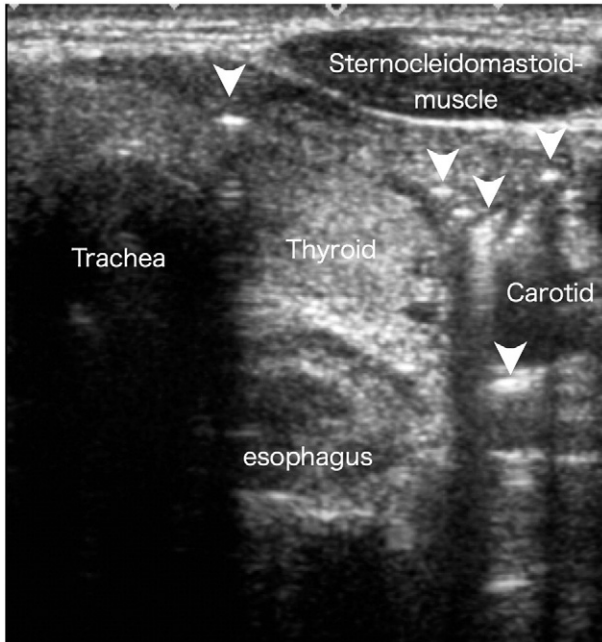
Ultrasound. Each arrow head showed air in the deep neck space, which was detected as high echoic spots with shadow. The air was distributed around the pharyngoesophagus lesion rather than trachea.
